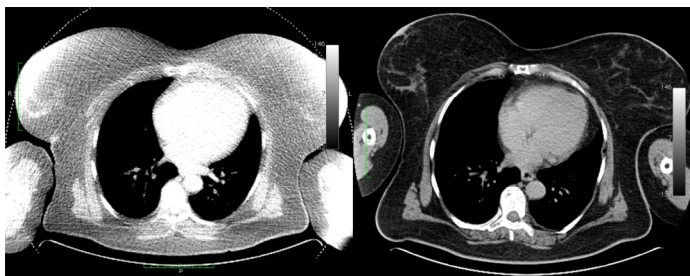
Beam hardening artefacts in a large patient (height: 175 cm, body weight: 120 kg) at the edge of the field of view are evident in the image of the low dose CT (140 kV, 230 mAs) on the left and have disappeared in the image on the right after conventional CT parameters (140 kV, 300 mAs) have been applied.
